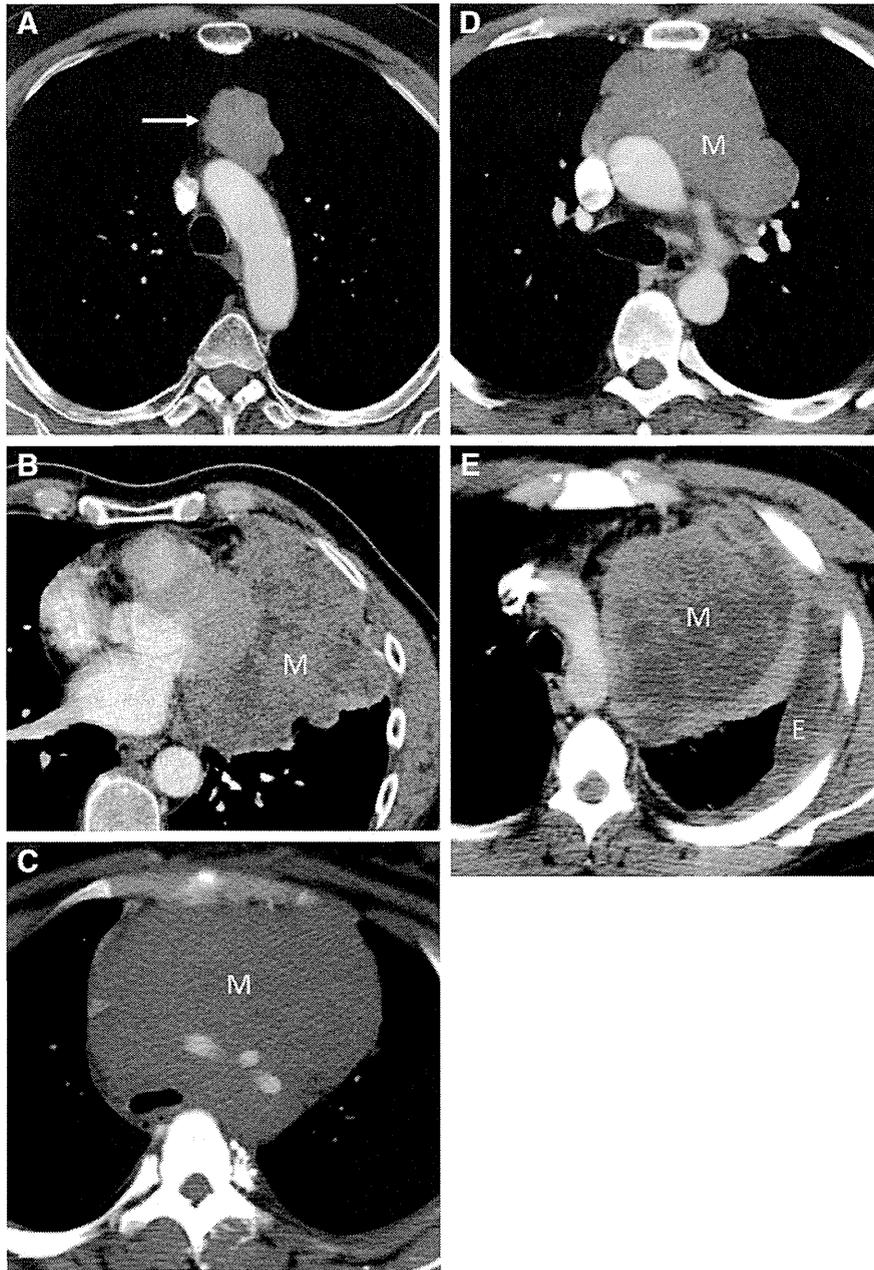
Lesions identifiable on imaging with clinical context. *A*, Coned-down contrast-enhanced axial CT of a 43-year-old man with myasthenia gravis demonstrates a well-defined, lobular soft tissue mass (arrow) in the anterior mediastinum. In a patient older than 40 years of age, the imaging appearance and clinical history are typical of a thymoma, which was confirmed at the time of surgery. *B*, Coned-down contrast-enhanced axial CT of a 38-year-old with chest pain demonstrates a large, lobular mass (M) originating in the left anterior mediastinum. The central regions of low attenuation represent necrosis. Note the extension of tumor around the left heart with obliteration of the adjacent fat plane. CT-guided biopsy revealed thymic carcinoma and cardiac invasion was confirmed at the time of surgery. *C*, Coned-down contrast-enhanced axial CT of a 33-year-old woman presenting with fever and weight loss demonstrates a large soft tissue mass (M) in the anterior mediastinum that extends into the middle mediastinum and insinuates itself around the great vessels. The infiltrative nature of this mass is characteristic of lymphoma and enables differentiation from other anterior mediastinal masses, such as thymoma. *D*, Coned-down contrast-enhanced axial CT of a 37-year-old man presenting with chest pain demonstrates a large, homogeneous, lobular mass (M) in the anterior mediastinum. Elevated serum lactate dehydrogenase and slightly elevated serum β -HCG levels were present and seminoma was confirmed at biopsy. *E*, Coned-down contrast-enhanced axial CT of a 28-year-old man presenting with chest pain, weight loss, and elevated serum α -FP demonstrates a large heterogeneous mass (M) originating in the left anterior mediastinum and extending into the left hemithorax. Regions of low density represent tumor necrosis. Biopsy revealed NSGCT. Note the loculated left pleural effusion (E), which was found to represent metastatic disease to the left pleura at the time of surgery.
